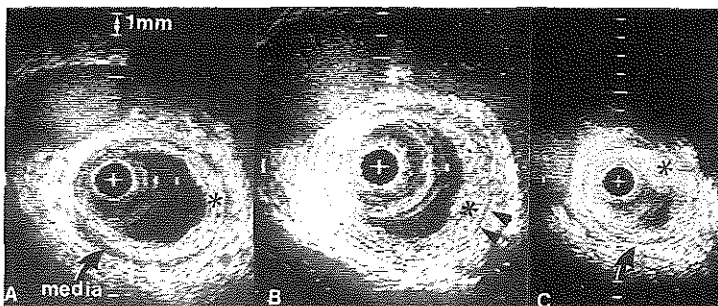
Ultrasonic cross-sections obtained in vivo (30 MHz) in a patient undergoing balloon angioplasty of the superficial femoral artery. The cross-sections (A to C) are taken from 3 different levels in the femoral artery and are arranged proximal to distal. A, proximally the lumen is not obstructed. There is evidence of diffuse intimal thickening (asterisk). The dark layer corresponds with the hypoechoic media (bold arrow). B, more distally the lesion (asterisk) is seen to expand progressively, resulting in conspicuous medial thinning at 3 o'clock (arrowheads). C, finally the ultrasound catheter images the atherosclerotic lesion (asterisk) casting a shadow at 1 o'clock. Between 1 and 4 o'clock the lesion prevents visualization of the media. Media is visible between 5 and 1 o'clock (bold arrow). At 11 o'clock a vein is noted (calibration 1 mm).
